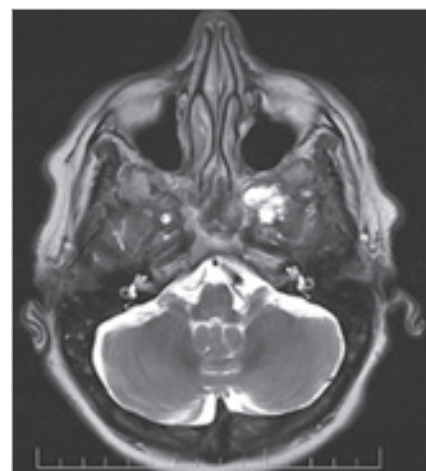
MRI of the tumor – third case.
